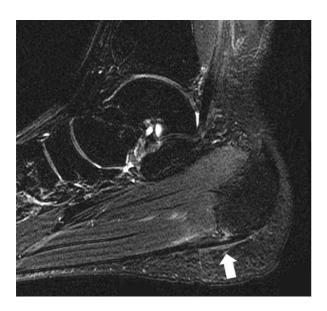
T2-weighted fat-saturated image at first presentation shows hyperplasia of the plantar fascia insertion at the calcaneus (arrow).
